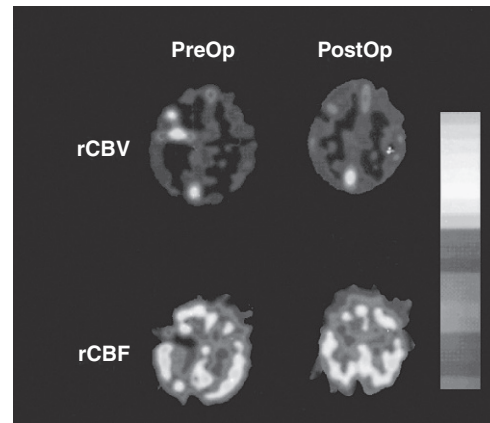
Example of single-photon emission computed tomography (SPECT). Double-label methodology is used to simultaneously image both regional cerebral blood flow (rCBF) (SPECTamine; ^{131}I -iodoamphetamine) and cerebral blood volume (rCBV) (technetium Tc99m-labeled red blood cells [RBCs]). The lookup table is relative, and the lighter shades reflect increasing flow or volume. Flow and volume imaging currently cannot be quantitated (as opposed to positron emission tomography techniques). This patient had a temporal cerebral arteriovenous malformation (AVM), and these scans were obtained before (PreOp) and after (PostOp) surgery. The CBF was normal except for a flow defect that corresponded to the AVM location demonstrated on magnetic resonance imaging. The CBF tracer does not image the fistula because there are no capillaries. In the rCBV image, a hot spot can be seen on the posterior midline that represents the sagittal sinus. The larger temporal enhancement is the AVM nidus; the smaller one is a large draining vein. (Courtesy Isak Prohovnik, PhD, and W.L. Young, MD, Columbia University.)
